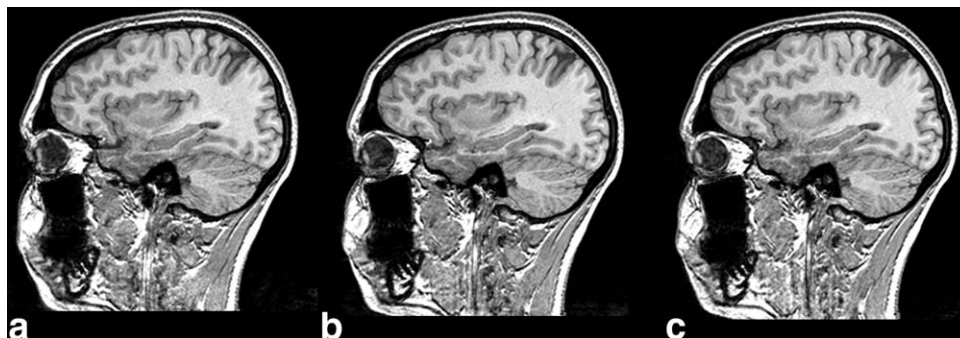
T1-weighted 3D GRE volunteer images using (A) the clinical routine implementation, (B) the identical protocol with optimized gradients, and (C) an optimized sequence with slight protocol adaptations. Images have identical windowing. The acoustic noise levels are (A) 89.0 dB(A), (B) 77.3 dB(A), and (C) 72.2 dB(A).
